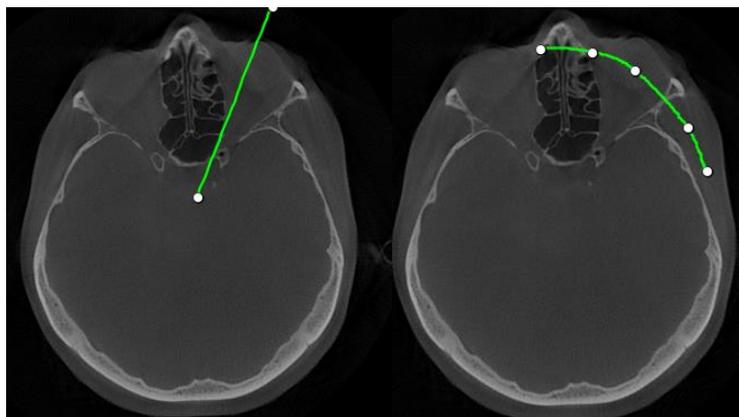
Left orbital fracture with surgical reconstruction of the orbital floor: (a) Individualized coronal oblique reconstructions of the orbit and left maxillary sinus using cone-beam computed tomography (CBCT). CBCT was able to provide information on the involved hard and soft tissues of the orbits. (b) CBCT sagittal view of the left orbital floor.
